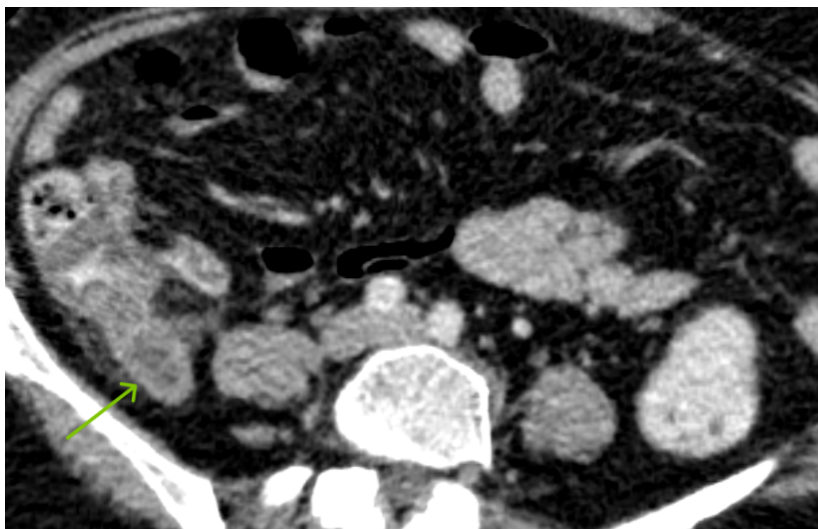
(B): CT: Dilated appendix with wall enhancement and periappendiceal fat stranding
